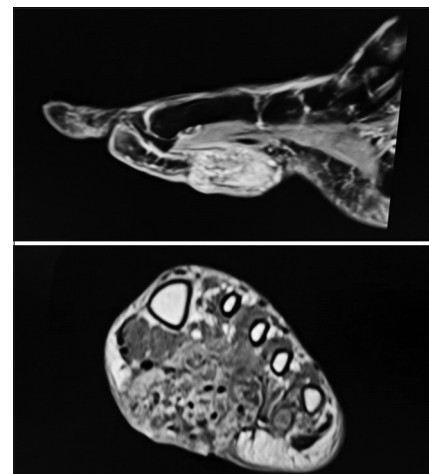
Magnetic resonance imaging left foot in sagittal and coronal sections showing eumycetoma without bony involvement
